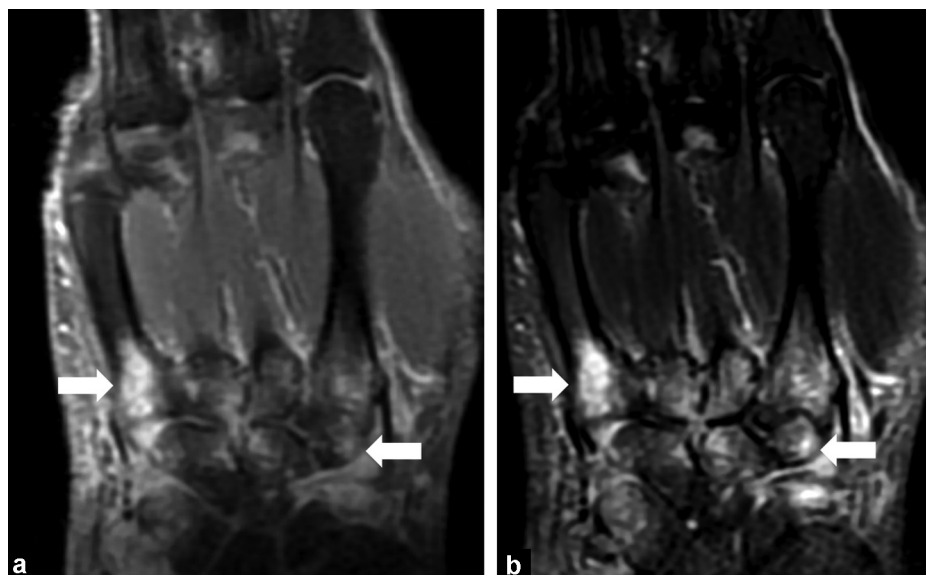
Fifty-six-year-old man with rheumatoid arthritis. (a) Coronal contrast-enhanced two-dimensional spin-echo (SE) T1-weighted Dixon water-only image and (b) coronal two-dimensional SE T2-weighted fat-saturated image show similar appearance of carpal and metacarpal bones osteitis (arrows).
